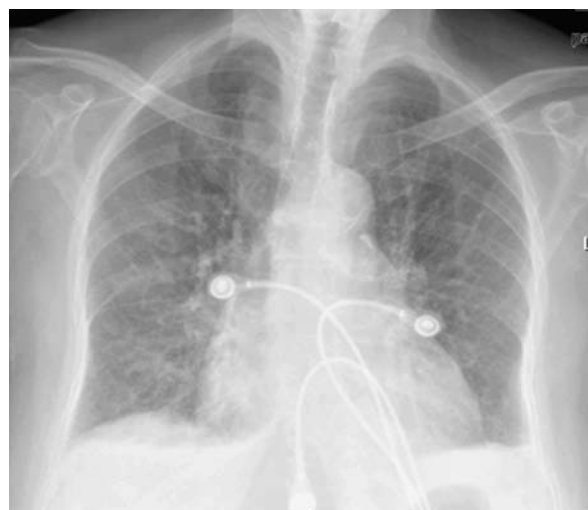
Chest radiography shows moderate-to-severe pericardial effusion without evidence of cardiac tamponade.
